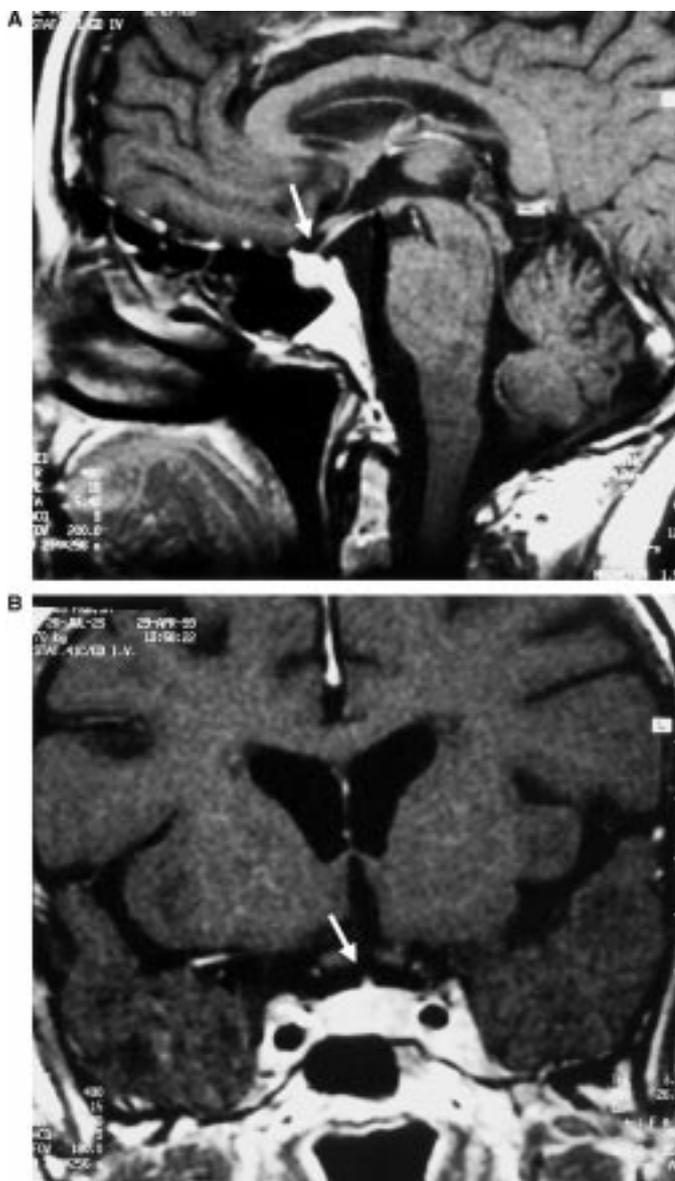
Contrast-enhanced computed tomography of the pituitary gland in sagittal (A) and coronal (B) planes at first presentation. In both views there is enlargement of the pituitary gland which extends beyond the sellar diaphragm (arrow in A). The entire pituitary takes up the contrast medium with accentuation of a small rim along the diaphragm (“dural tail”, arrow in B)
